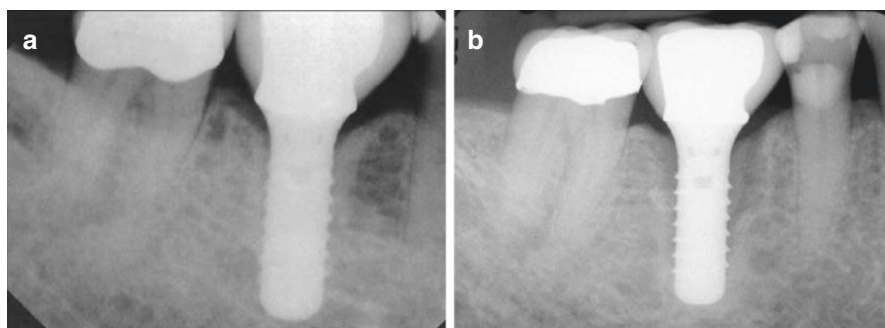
(a) This radiograph was exposed 6 years before the one seen in (b). During that time, there was substantial bone loss both radiographically and clinically. The genesis of the bone loss was excess cement on the mesial surface of the implant
